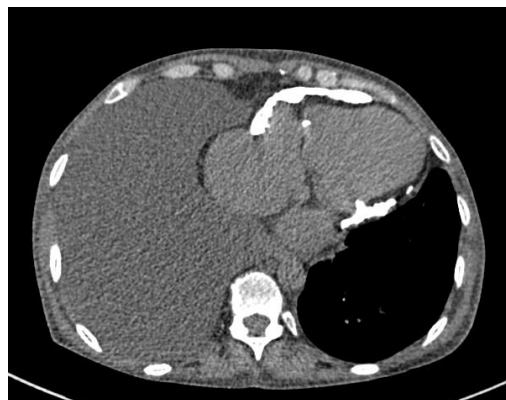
Axial non-contrast thoracic CT image demonstrating extensive circumferential pericardial calcifications with associated pericardial thickening exceeding 4 mm. Note the right atrial enlargement and dilatation of the inferior vena cava, consistent with chronic right-sided pressure overload secondary to constrictive pericarditis
